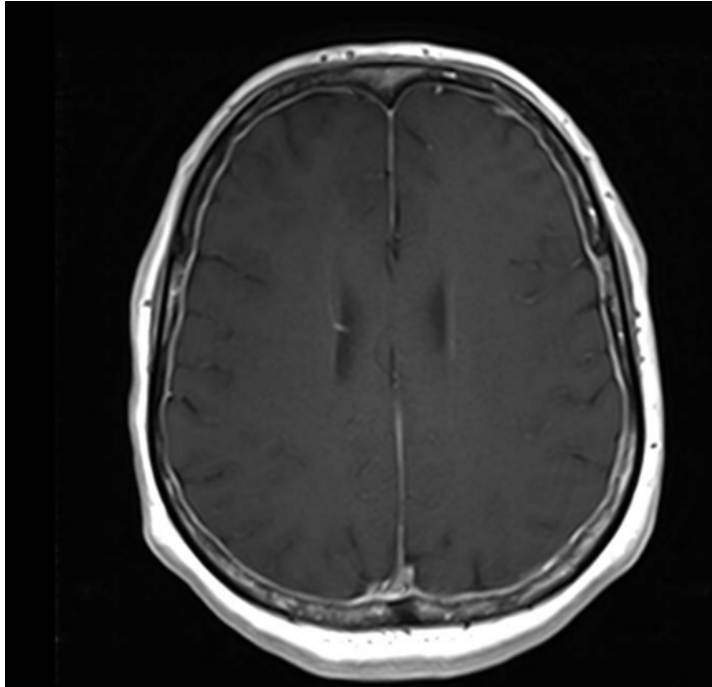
Axial T1-weighted post-contrast MR image of the brain shows diffuse regular pachymeningeal thickening and enhancement.
